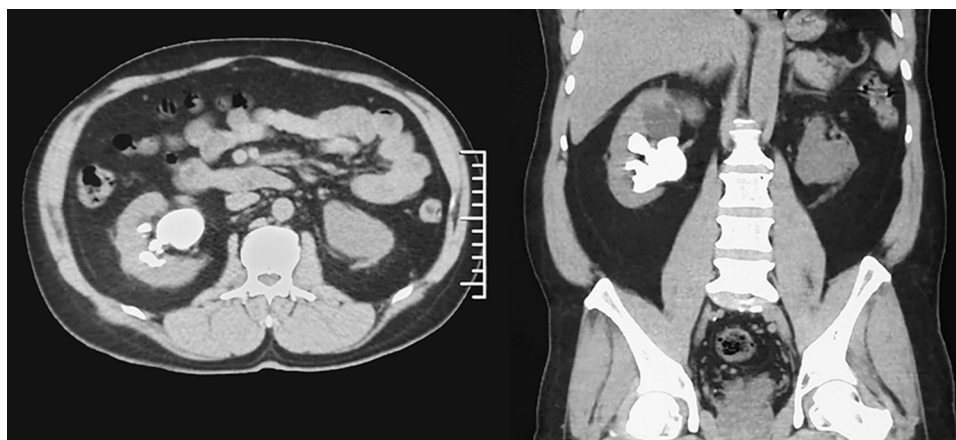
CT scan showed right complete staghorn stone with left proximal ureteral stone.
